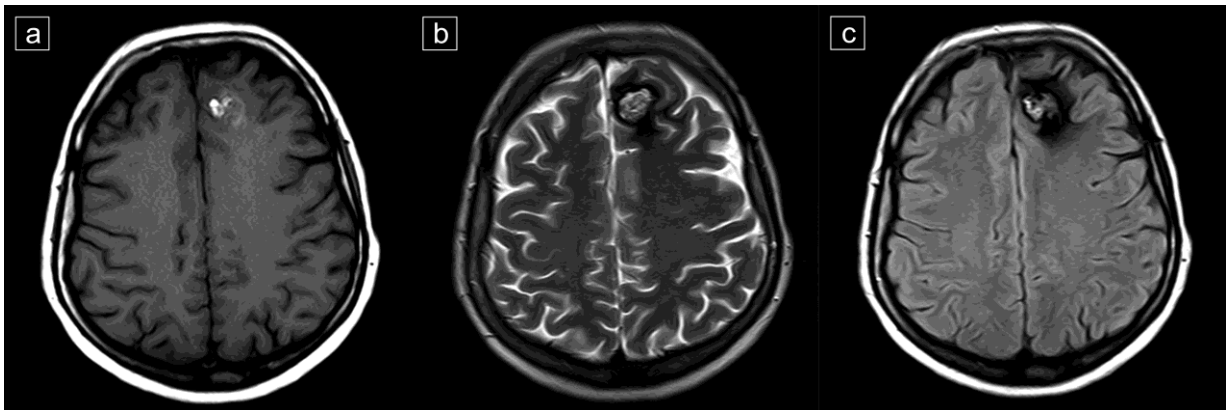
a-c. MRI examination – large subcortical CCM in the left frontal lobe. Hyperintense lesion in T1-weighted image (a), T2-weighted (b), and in FLAIR sequence (c). In T2-weighted and FLAIR - visible wide hypointense hemosiderine rim after bleeding.
